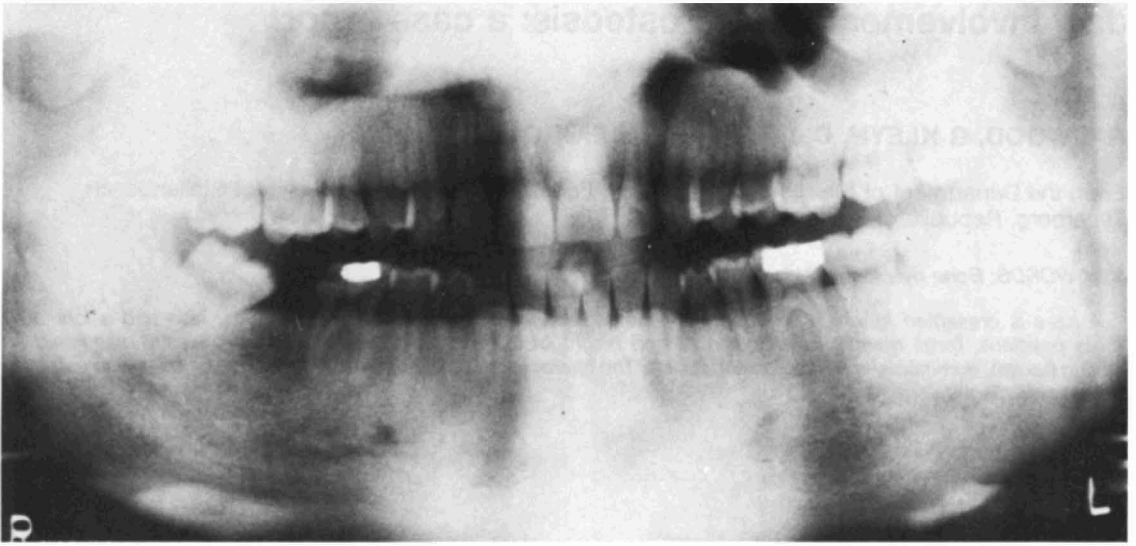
Panoramic radiograph showing generalized increased radiopacity of bone and gross increased height of the mandible.
